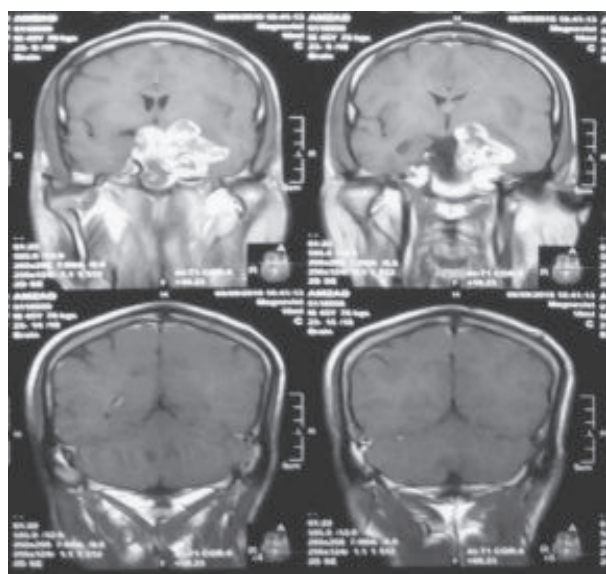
Evidence of compression on optic chiasma & third ventricle and involvement of cavernous sinus in a case of pituitary macroadenoma as shown by contrast enhanced MR images
